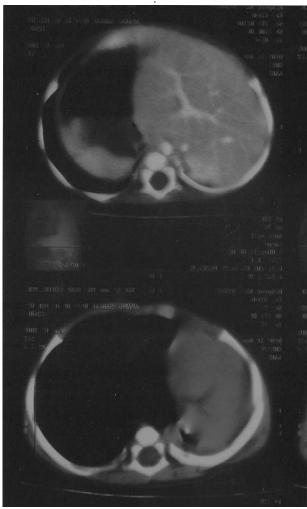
CT scan of the chest showing absence of right lung.
